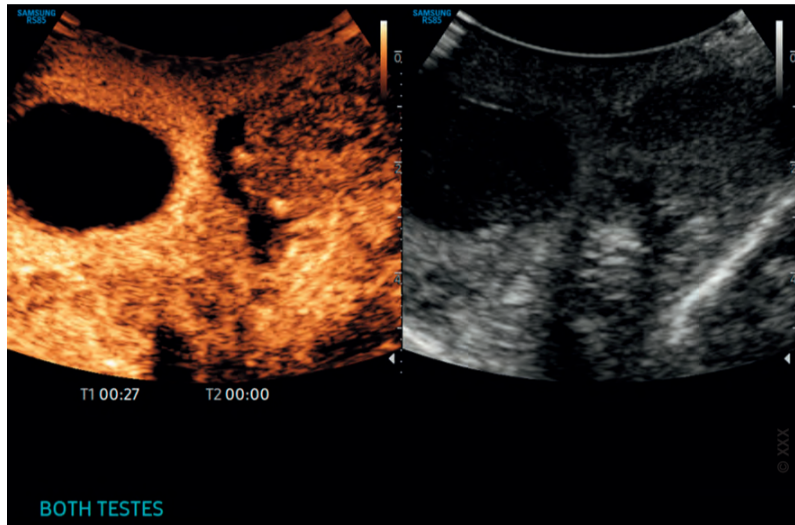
Image of a contrast enhanced testicular ultrasound demonstrating right testicular infarction.
